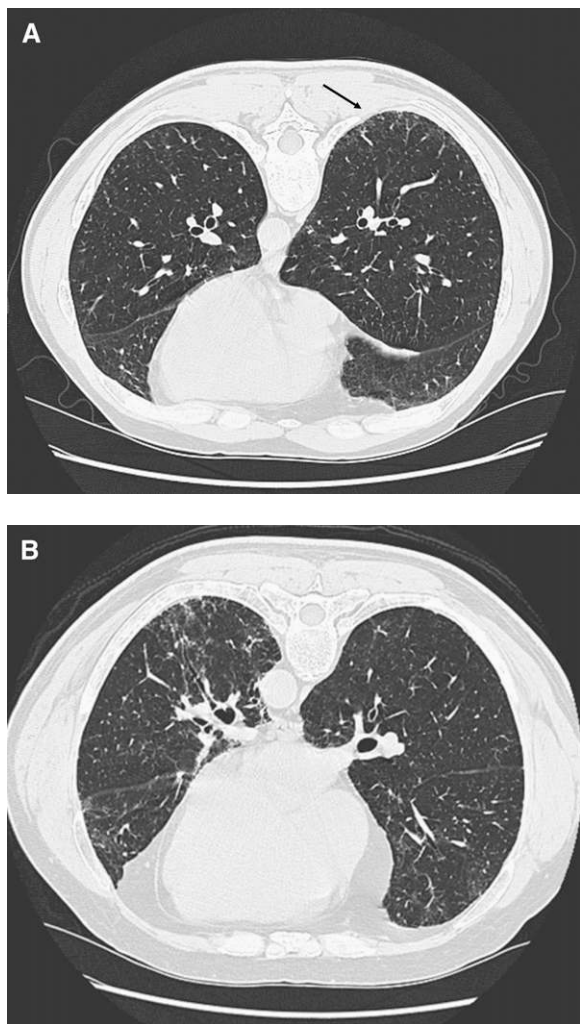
Representative abnormal high-resolution computed tomography (HRCT) scan images from two first-degree relatives without a prior diagnosis of idiopathic pulmonary fibrosis. (A) shows mild subpleural opacities (*arrow*) in an asymptomatic 50-year-old man. (B) An HRCT image from his brother, who was a 62-year-old man with progressive exertional dyspnea, shows moderate subpleural fibrosis and honeycombing.
